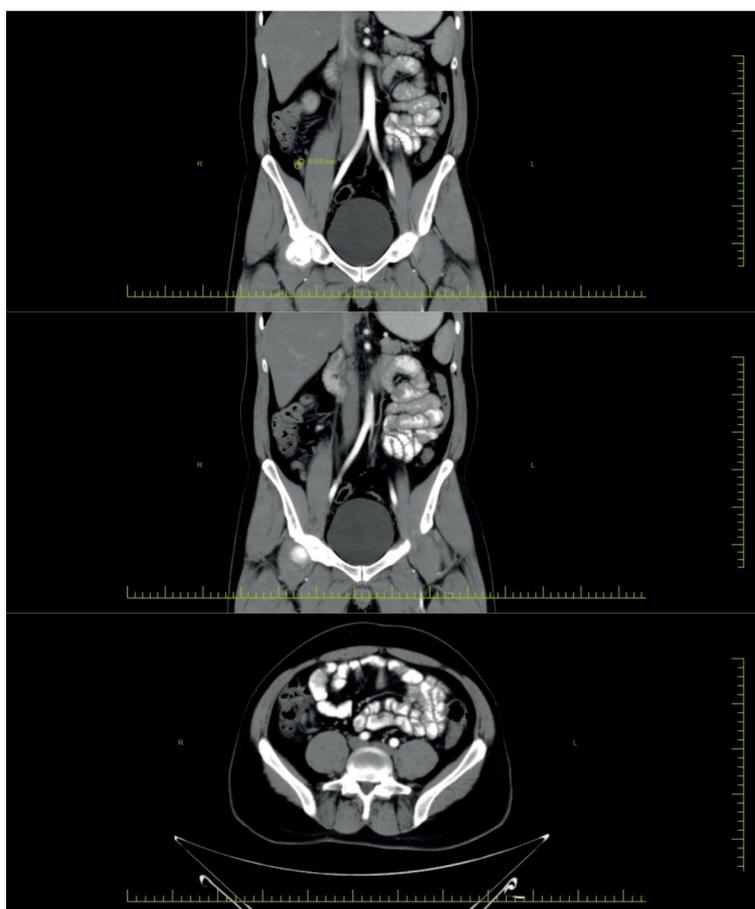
Computed tomography image: there is stranding in pericecal adipose tissue and dilatation (6.83 mm) in the appendix.
